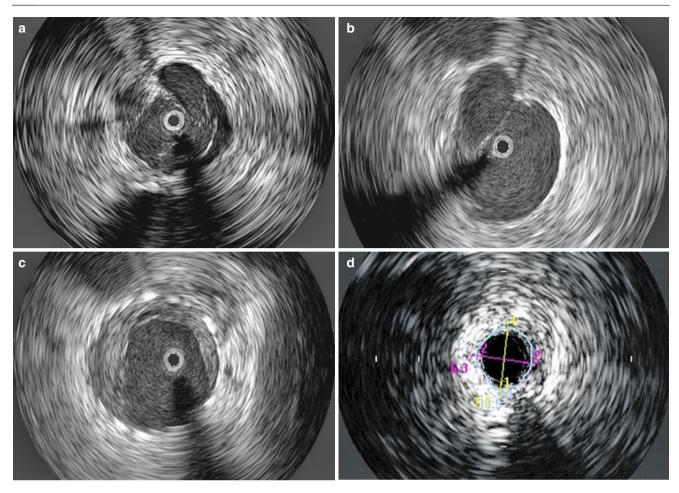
Images obtained by venous intravascular ultrasound (IVUS):
